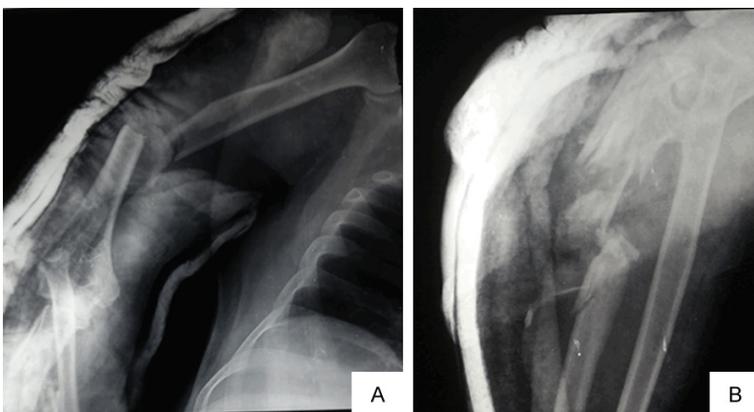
Pre-operative X-rays: (A) Fracture shaft humerus, (B) Monteggia fracture-dislocation.
